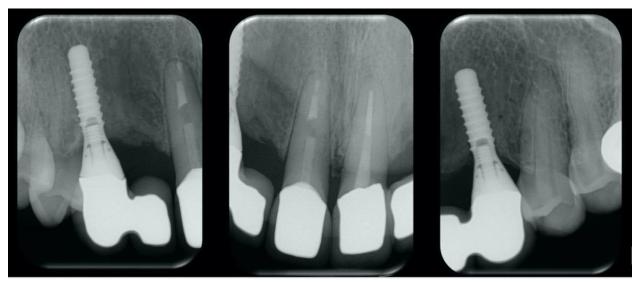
5-year follow-up periapical radiographs.
